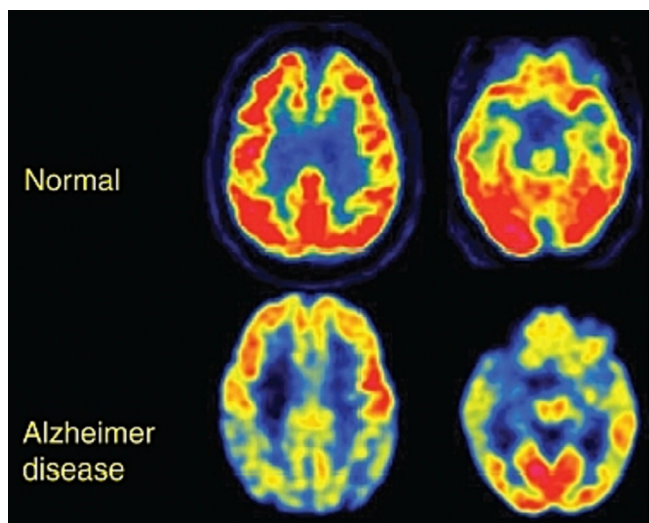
Trans axial ^{18}F FDG-PET image of normal and patient with Alzheimer's disease. Where warm colours indicate normal metabolic activity and cool colours indicate reduced metabolic activity (Johnson et al., 2012).
